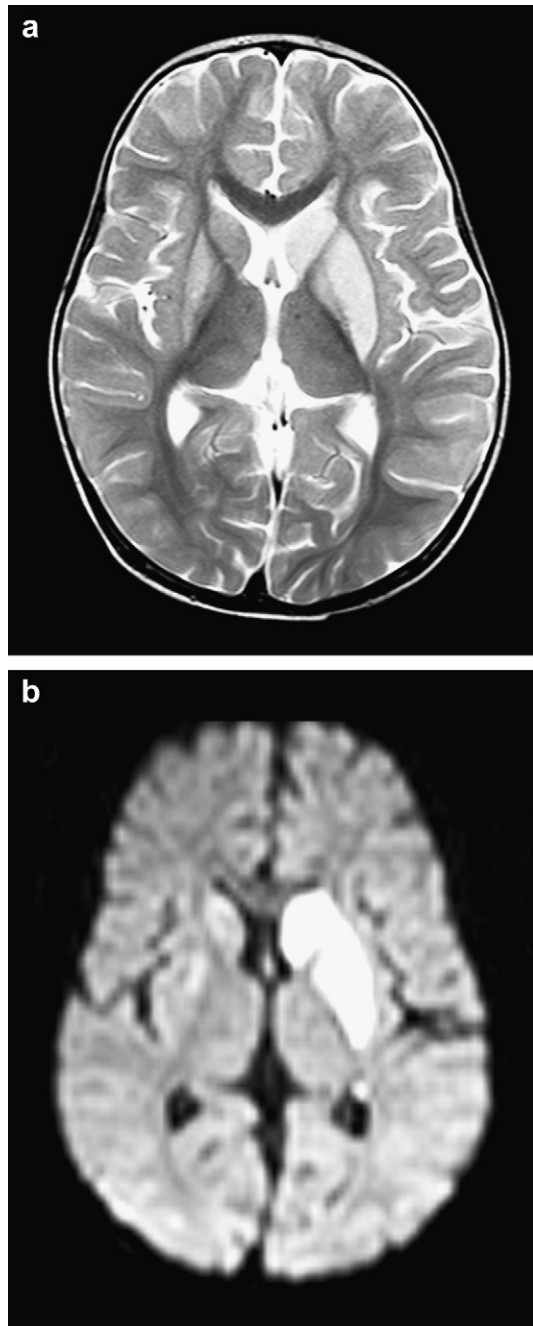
(a) Axial T2-weighted image and (b) diffusion-weighted image of patient 3. (a) shows bilateral but asymmetric involvement of the basal ganglia: the left putamen and head of caudate show swelling and extensive increased signal. (b) demonstrates restricted diffusion in the left basal ganglia.
